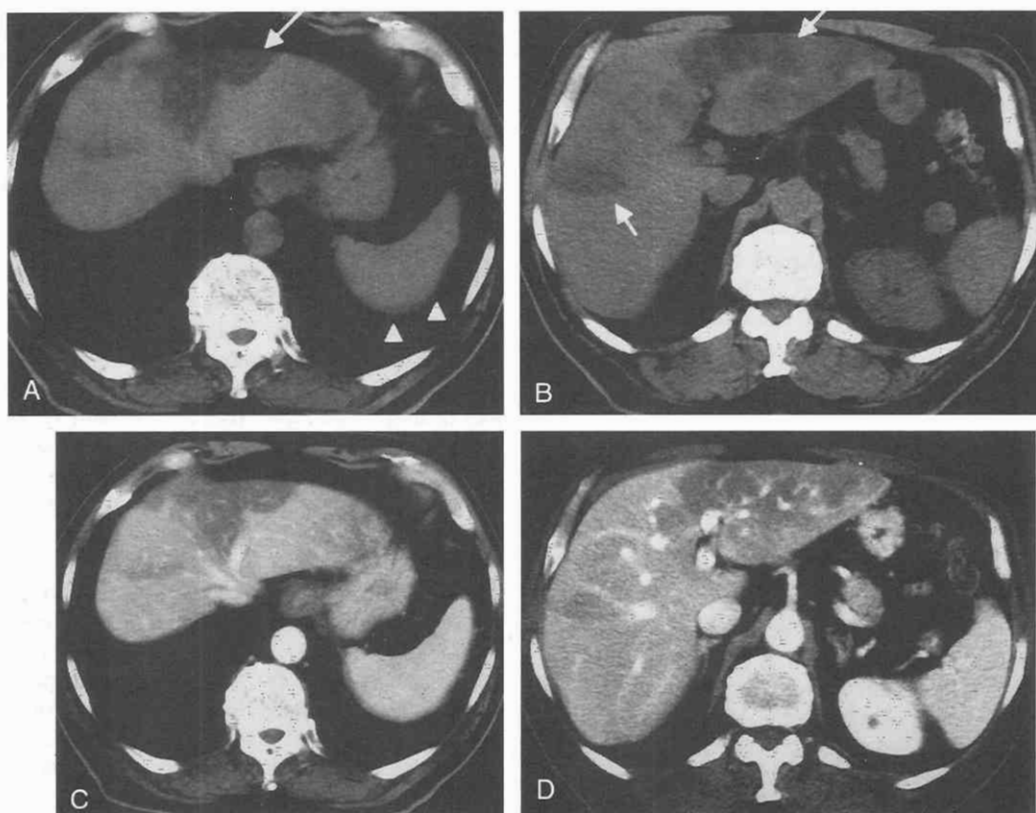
Hyperechoic lesion, visualized by ultrasound, in a 60-year-old man with a prior history of colorectal carcinoma. A and B, Unenhanced CT scans show hypodense areas in both liver lobes (arrows) without the impression of tumor with attenuation similar to fat; compare the splenic parenchyma (arrowheads). C and D, Contrast medium application does not lead to visualization of displacement of the blood vessels. These findings are pathognomonic of focal fatty infiltration.
